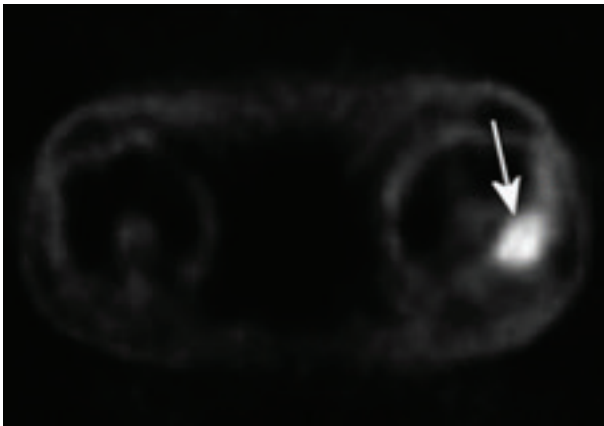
PET/CT identifies area of major metabolic activity in the left lateral femoral epicondyle.
